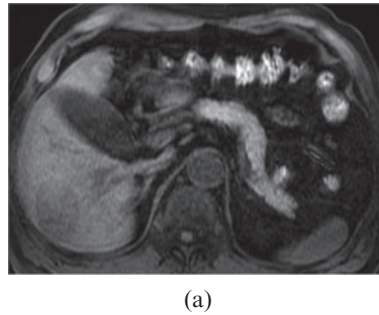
(a) Pre-contrast T_1 weighted axial MRI of the liver. (b) A series of enhanced T_1 weighted MRI images at (left-right) 28 s, 42 s, 5 min and 20 min after the administration. The anterior portion of this lesion demonstrates a similar degree of enhancement to the surrounding liver parenchyma (arrow), while the posterior portion exhibits reduced enhancement (arrowhead).
